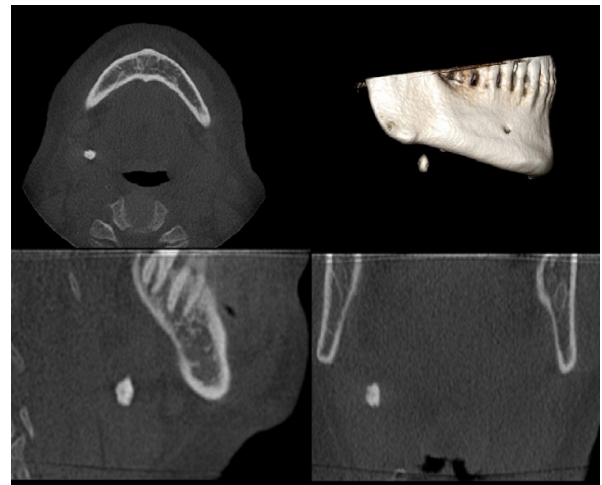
CBCT images of a sialolith in the right submandibular region.
